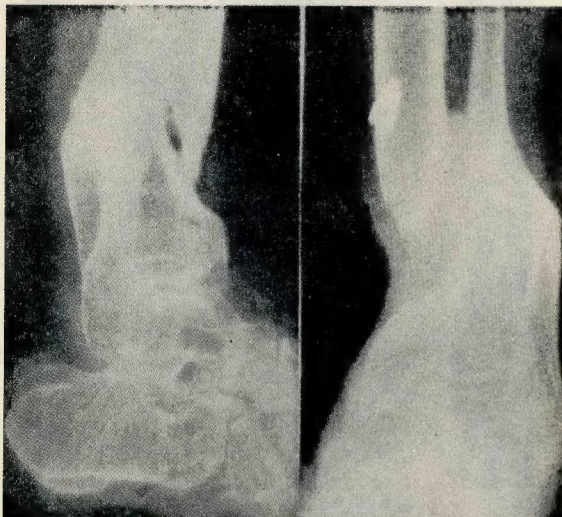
(Record No. 538, I.S.N. could not be remembered) Roentgenogram showing malunion of fracture of the lower third of tibia and fibula, left.
